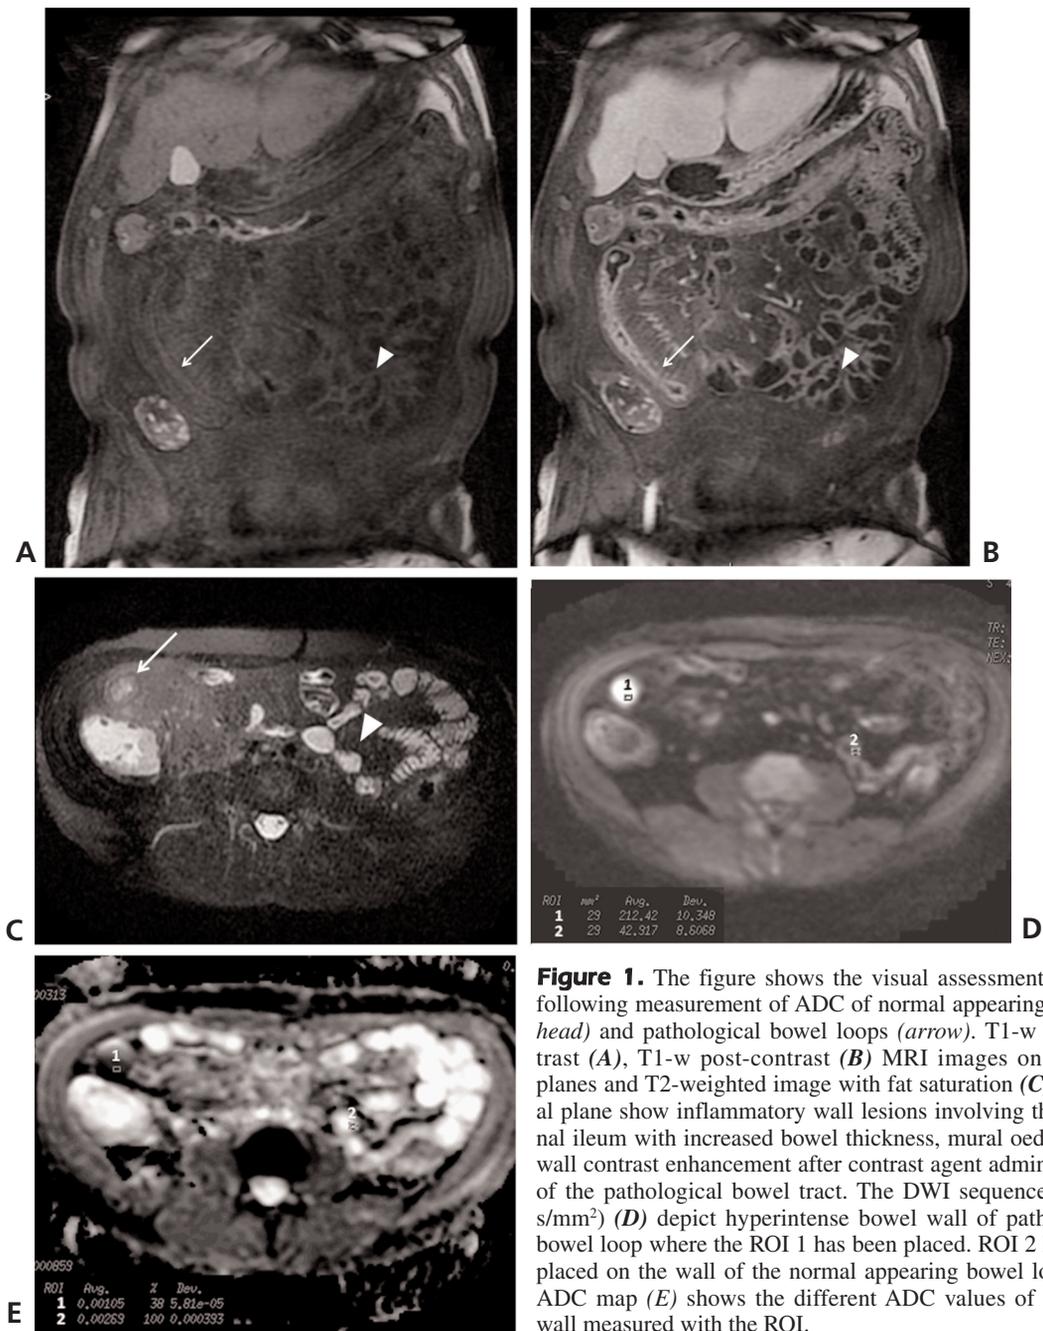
The figure shows the visual assessment and the following measurement of ADC of normal appearing (*arrowhead*) and pathological bowel loops (*arrow*). T1-w pre-contrast (A), T1-w post-contrast (B) MRI images on coronal planes and T2-weighted image with fat saturation (C) on axial plane show inflammatory wall lesions involving the terminal ileum with increased bowel thickness, mural oedema and wall contrast enhancement after contrast agent administration of the pathological bowel tract. The DWI sequence (b=800 s/mm²) (D) depict hyperintense bowel wall of pathological bowel loop where the ROI 1 has been placed. ROI 2 has been placed on the wall of the normal appearing bowel loop. The ADC map (E) shows the different ADC values of intestine wall measured with the ROI.
